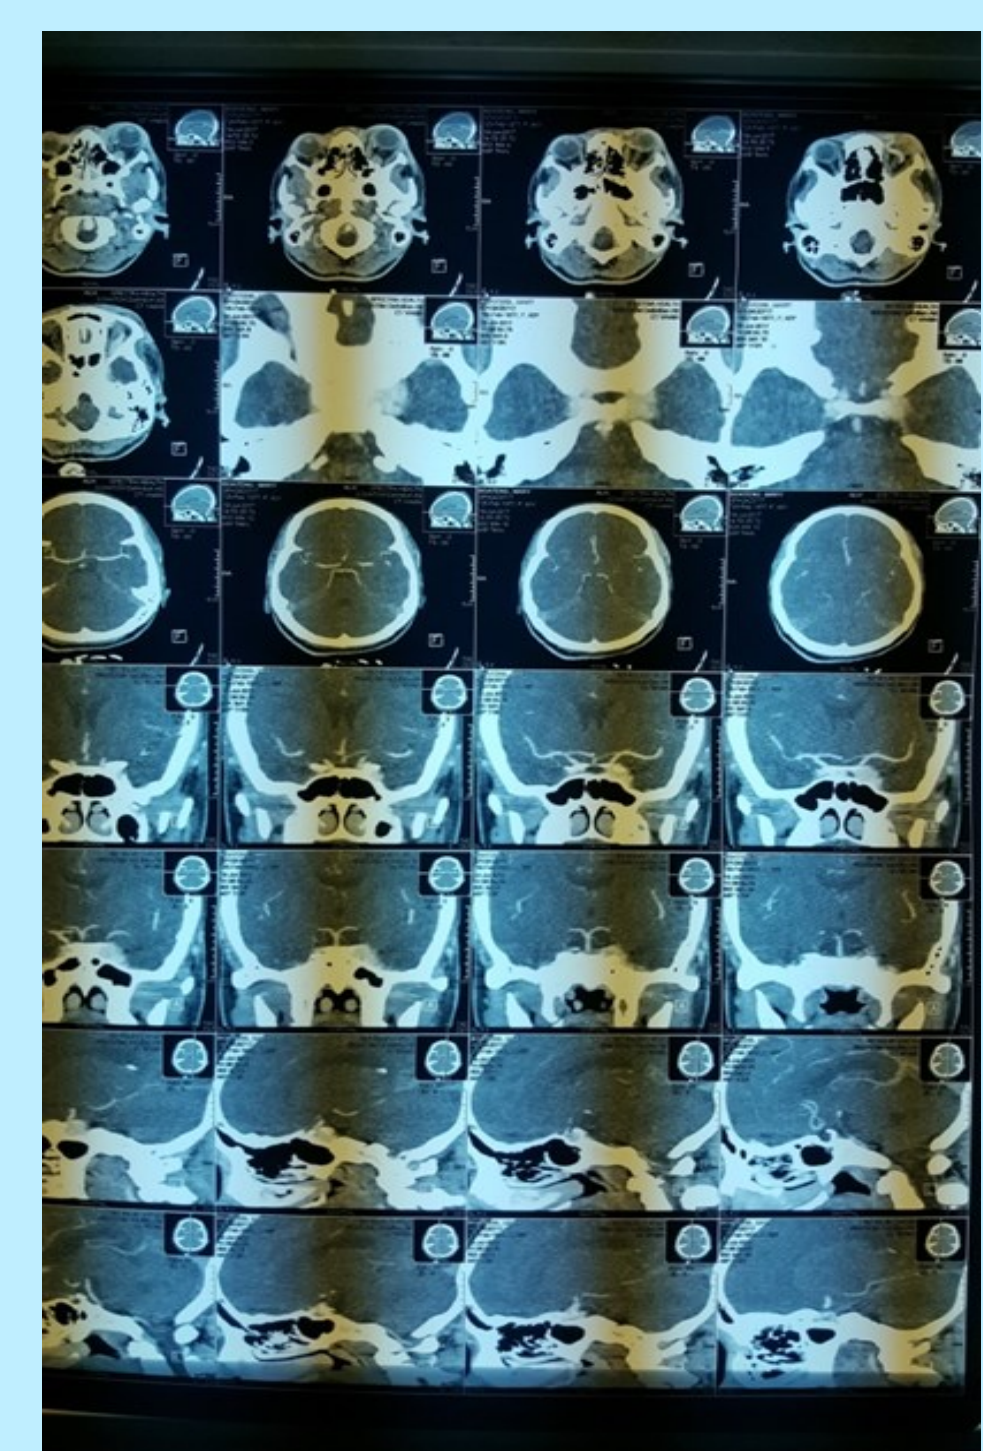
Contrast enhanced CT scan of brain parenchyma and vasculature
